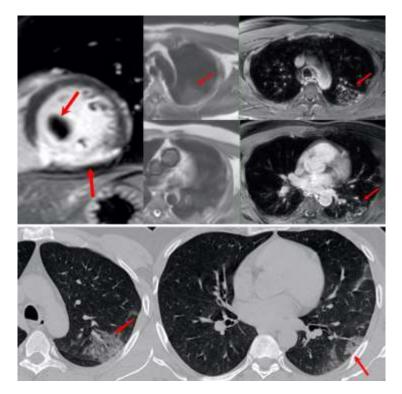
This 53-years old man had a recent myocardial infarct and came for cardiac MRI, which shows an inferior wall infarct with a thrombus in the left ventricle. Also seen in the lungs were wedge-shaped opacities that were shown to be typical of COVID-19 on a CT scan done immediately. His RR-PCR test came positive the next day.
